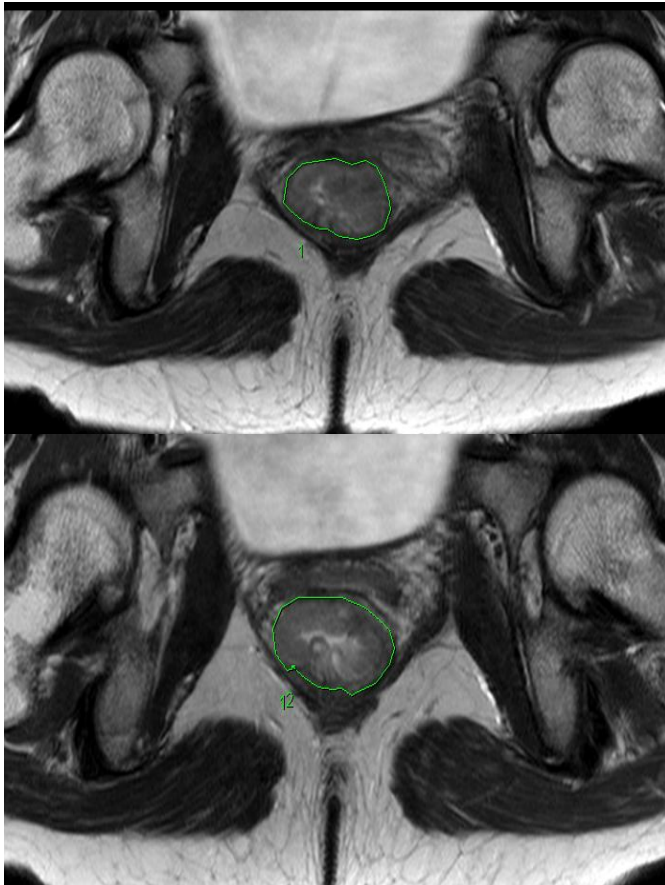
Tumour volumetry as performed on T2-weighted HR axial scans
